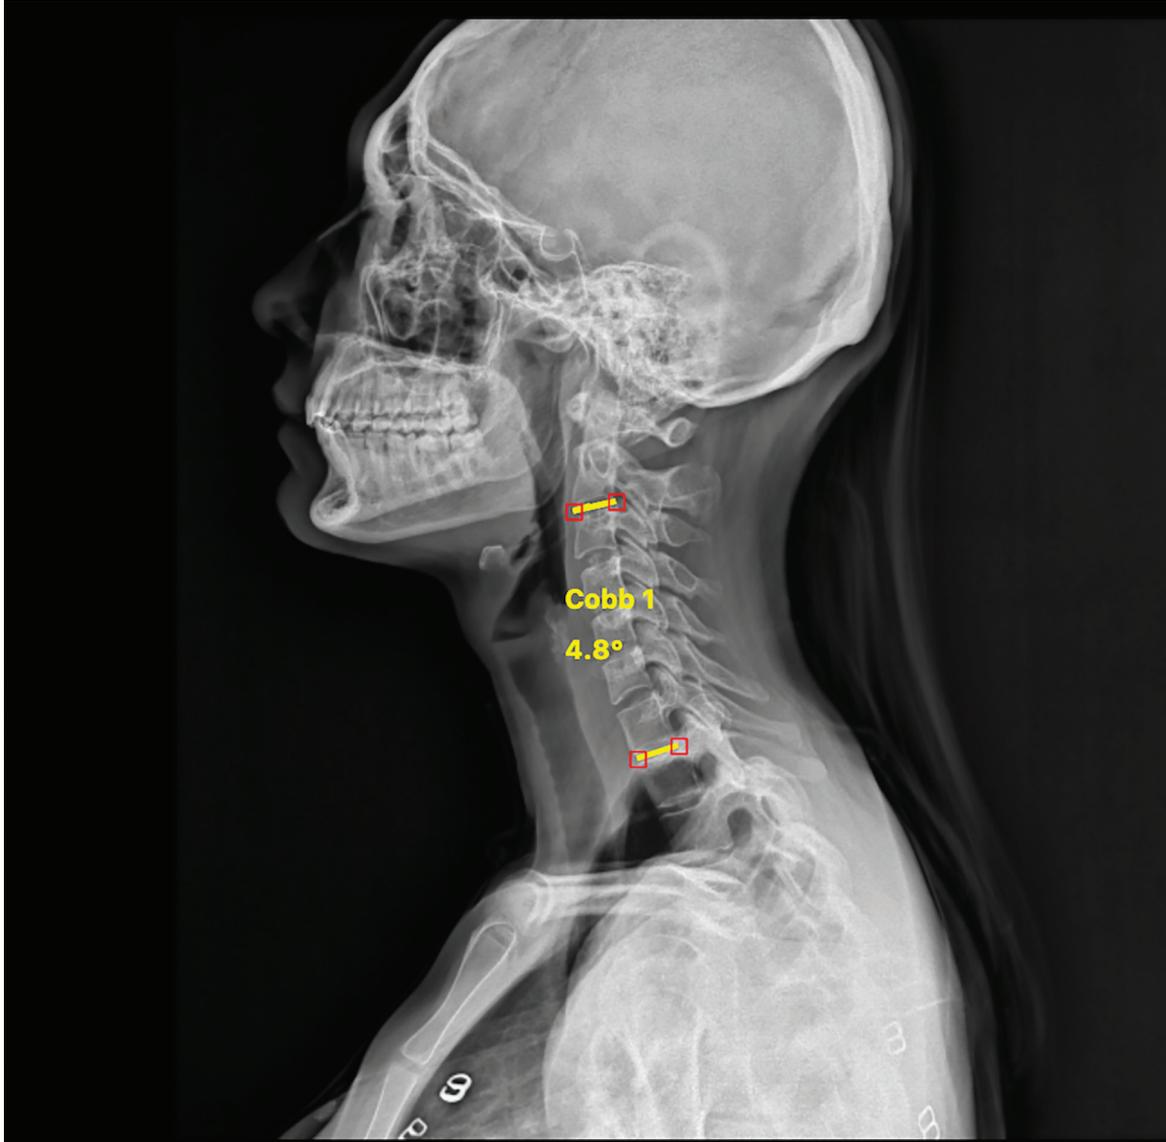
GCL (Cobb angle between C2 and C7) measurement on cervical lateral x-ray.
